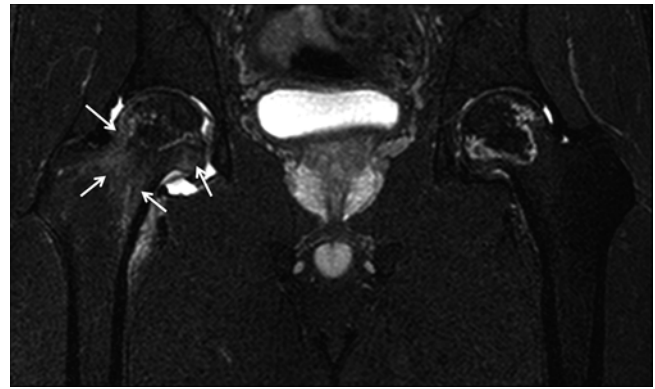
ON of both femoral heads. The patient has ON of both femoral heads. The right hip is painful, but the left hip is asymptomatic. Joint effusion at the right hip joint and diffuse bone marrow edema (*arrows*) of the right femoral head and neck are demonstrated on T2-weighted fat-suppressed coronal MR image
